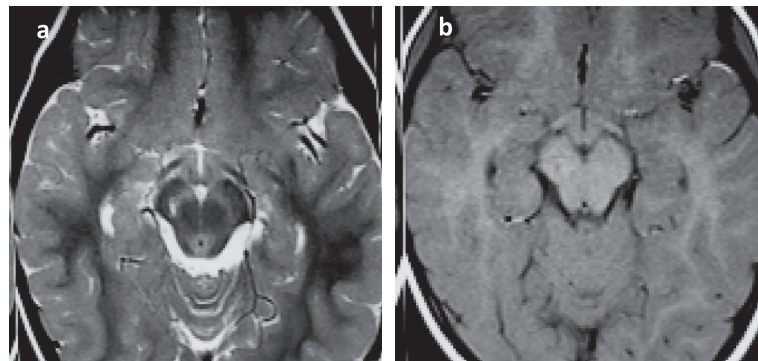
Axial brain MRI (a and b) showing increased signal of the right substantia nigra on T2 weighted images (a) with normal signal without contrast enhancement on T1 weighted images with gadolinium (b).
